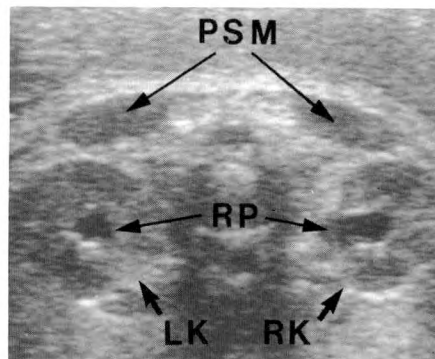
Transverse (A) and longitudinal (B) sonograms of fetus with bilateral mild pyelectasis (pelvis/kidney ratio of right kidney = 0.22). No caliceal dilatation is seen on longitudinal image. PSM = paraspinal muscles; RP = renal pelvis; LK = left kidney; RK = right kidney; P = medullary pyramids.
